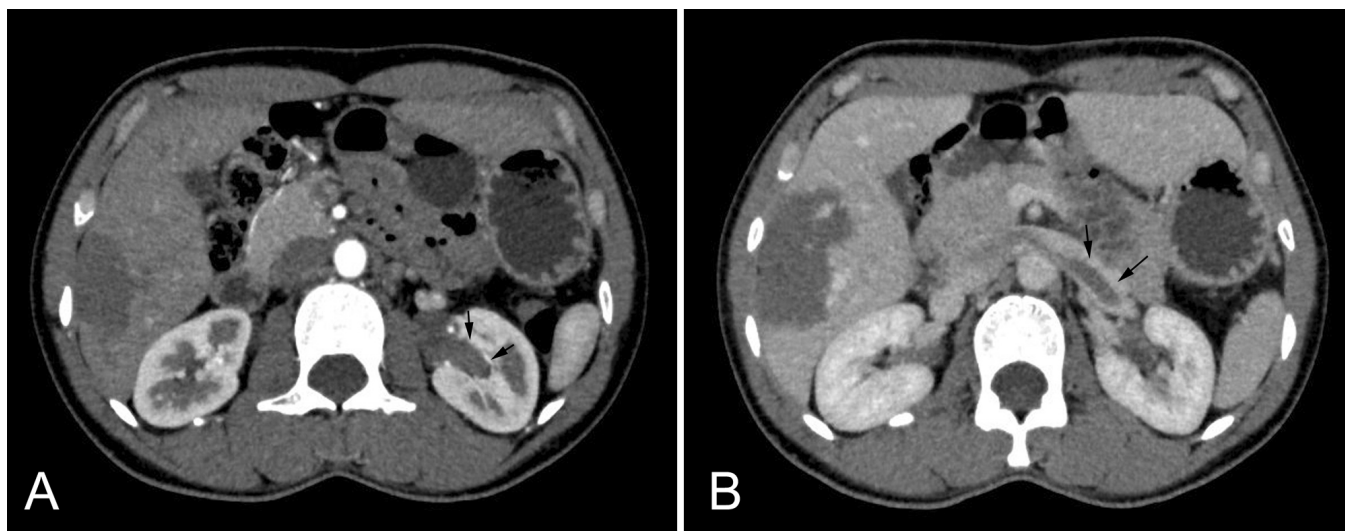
Radiographic examination of the lesions. A. Computed tomography (CT) scan showed a well-circumscribed lesion located in the central region of left kidney, protruding into the renal pelvic cavity (black arrow). B. Contrast CT scan revealed a filling defect in the left renal vein and was suggestive of venous tumor embolus (black arrow).
